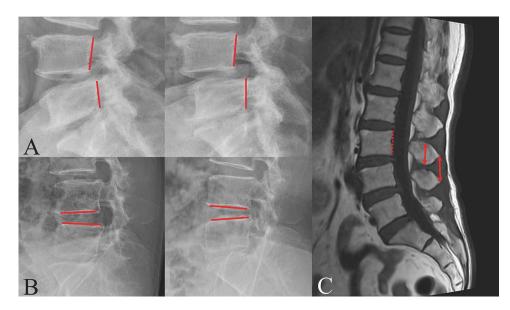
Figure I Functional lateral radiographs and magnetic resonance imaging. (A and B). Translation greater than 3 mm or changes in angulation greater than 9° subtended between solid lines on the lateral flexion and extension standing radiographs were considered to show segmental instability. C. To measure the height of the spinous process (anterior arrow), a line parallel to the posterior wall of the vertebral body (dotted line) was drawn first and the maximum length among all the slice lengths was obtained. Inter-spinous process distance (posterior arrow) was defined as the distance between midpoints of the spinous processes.
